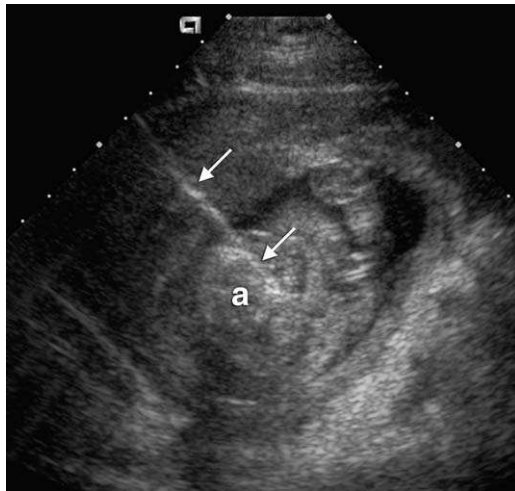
Transabdominal intraoperative ultrasound image reveals the radiofrequency ablation device (arrows) deployed within the abdomen of the acardiac fetus (a).
